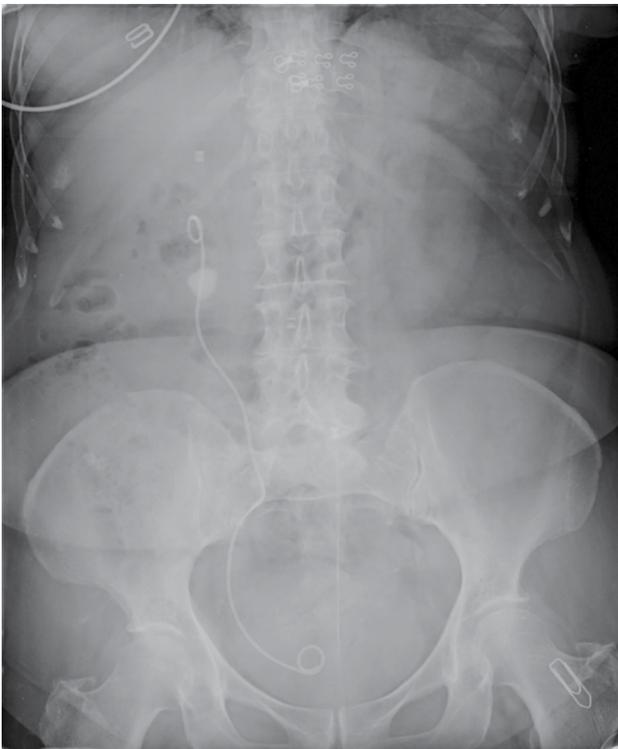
Preoperative plain X-ray of the kidney, ureter and bladder region demonstrating a sizable, radiopaque, right renal stone and an indwelling, right double-J stent.
